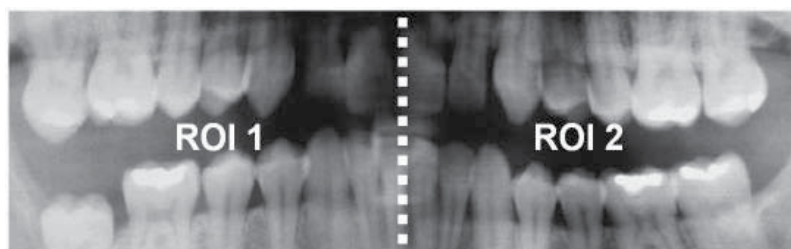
ROIs in a dental radiograph, left part (ROI 1), right part (ROI 2).
